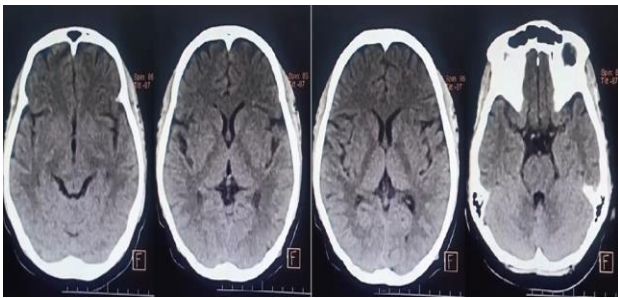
Patient CT scan.
